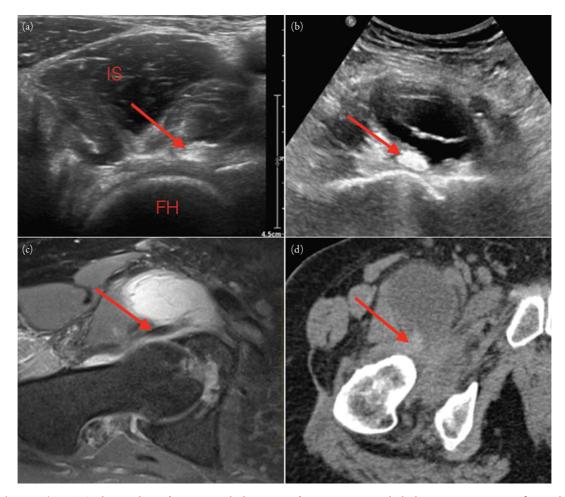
Iliopsoas bursa. This bursa is located anterior to the hip joint and communicates with the hip joint in up to 15% of normal asymptomatic individuals. Communication of this bursa with the hip joint is increased in the context of hip internal derangement as seen with any form of hip arthritis. On imaging, the iliopsoas bursa is typically located anterior to the hip joint and medial to the iliopsoas tendon. Panel (a) shows a grayscale sonographic image of the anterior hip in the transverse plane with a normal echogenic iliopsoas tendon (arrow). No iliopsoas bursal distention seen. Panel (b) is a grayscale ultrasound image of the anterior hip in the transverse plane showing a circumscribed mainly anechoic soft tissue mass with posterior acoustic enhancement and thin internal separations medial to the oval echogenic iliopsoas tendon (arrow). Axial magnetic resonance imaging (Panel (c)) and computed tomography (Panel (d)) images of the hip show a cystic appearing anterior hip soft tissue mass medial to the iliopsoas tendon (arrows). This mass is in the typical location of the iliopsoas bursa.
